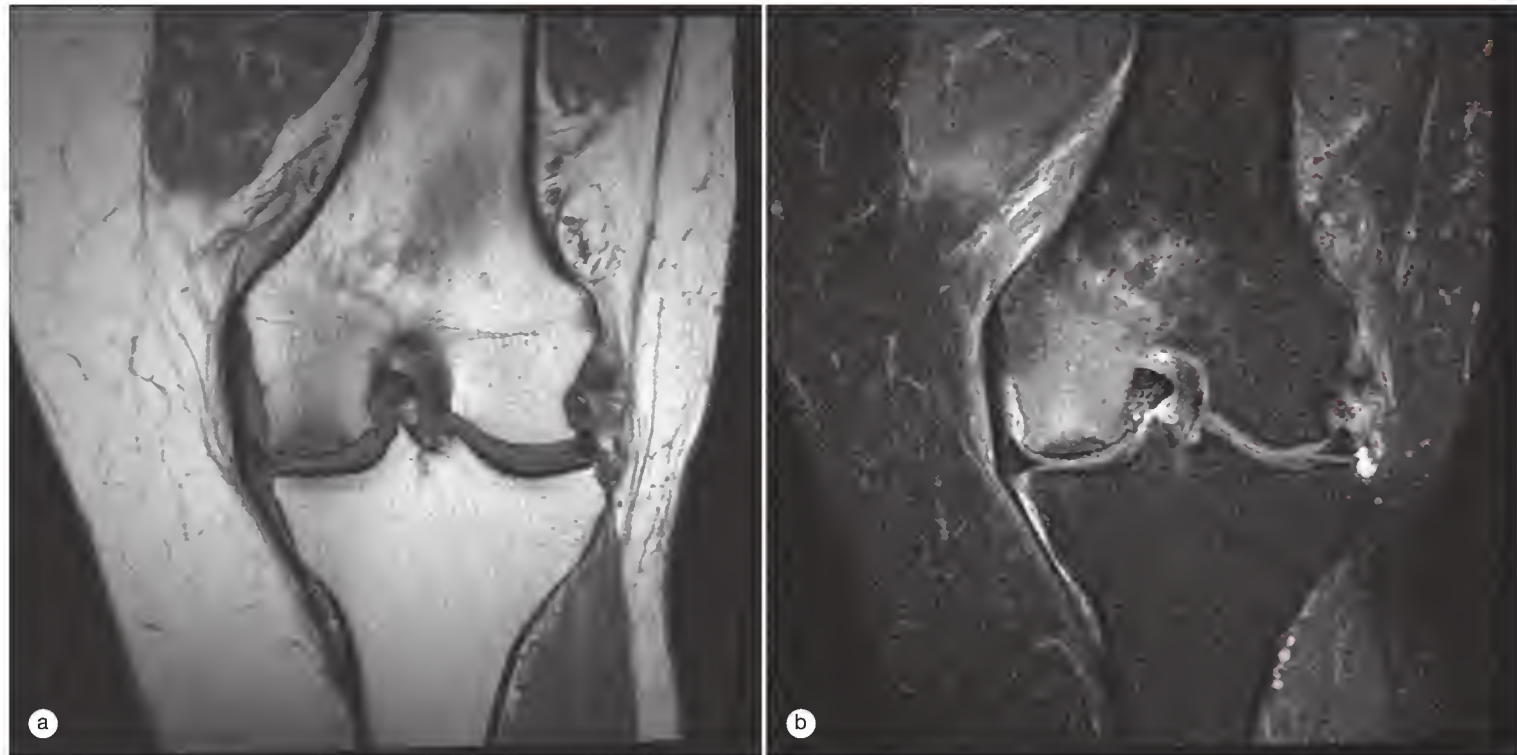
T1-weighted coronal magnetic resonance image of the knee (left) demonstrates subchondral linear dark signal with associated ill-defined low signal representing marrow edema. The proton-density fat-saturated coronal image (right) demonstrates marked marrow signal abnormality involving the medial femoral condyle with subchondral dark signal paralleling the articular surface. These findings indicate the presence of the now controversial entity known as *spontaneous osteonecrosis of the knee*.
